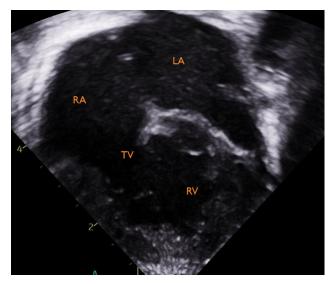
Apical 4C view 2D TTE – not feasible to see all 4 chambers in this view.
